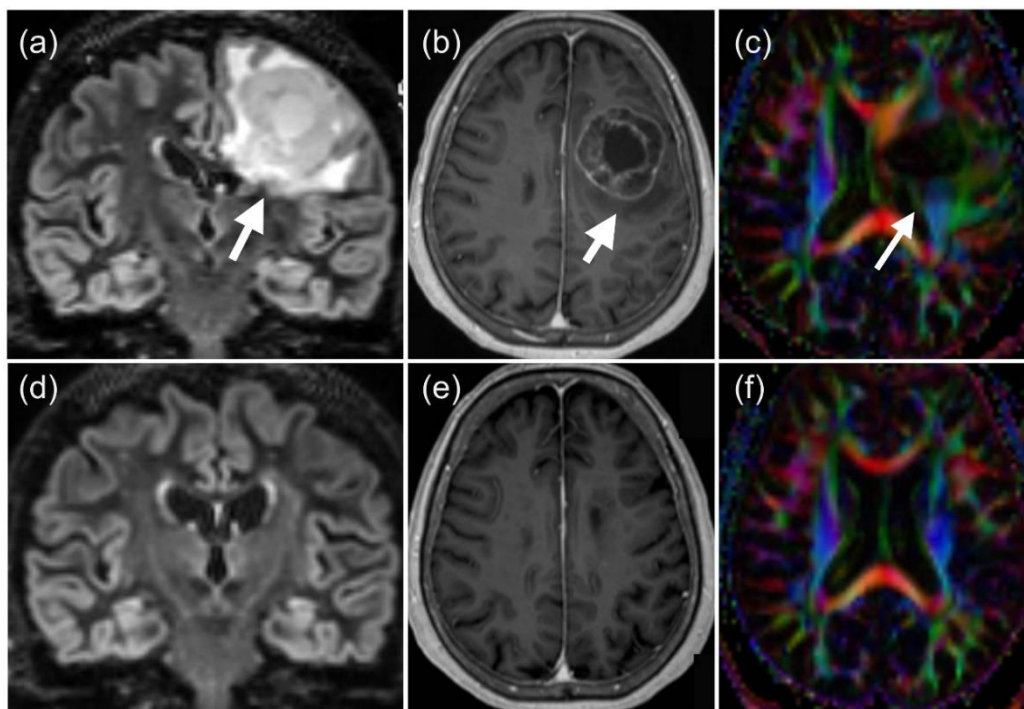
Multiparametric MRI of a solitary brain metastasis from lung cancer. (a)-(c): before radiotherapy. (d)-(f): 6 months after radiotherapy. (a) Coronal fluid attenuated inversion recovery (FLAIR) image showed a large expansile tumor
